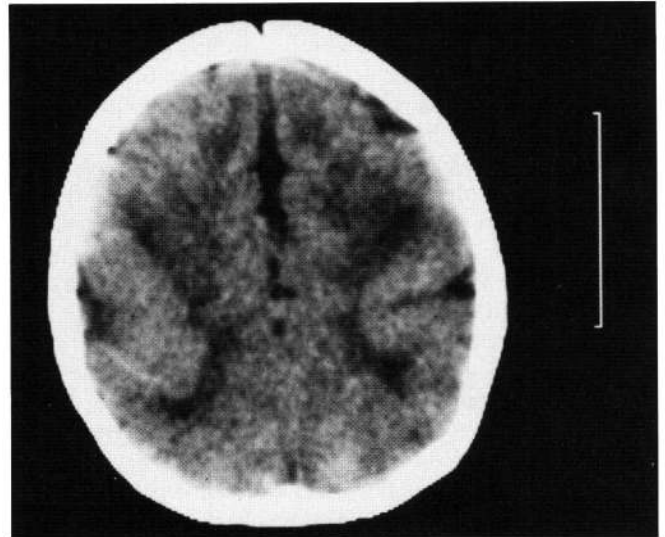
Pachygyria in a 7-month male with microencephaly from consanguineous parents. Transverse high CT-section shows deep bilateral sulcus bordered by thickened cortex. Bar on right is 5 cm. Thickness of abnormal cortex is several cm and should be less as 0.5 cm.
